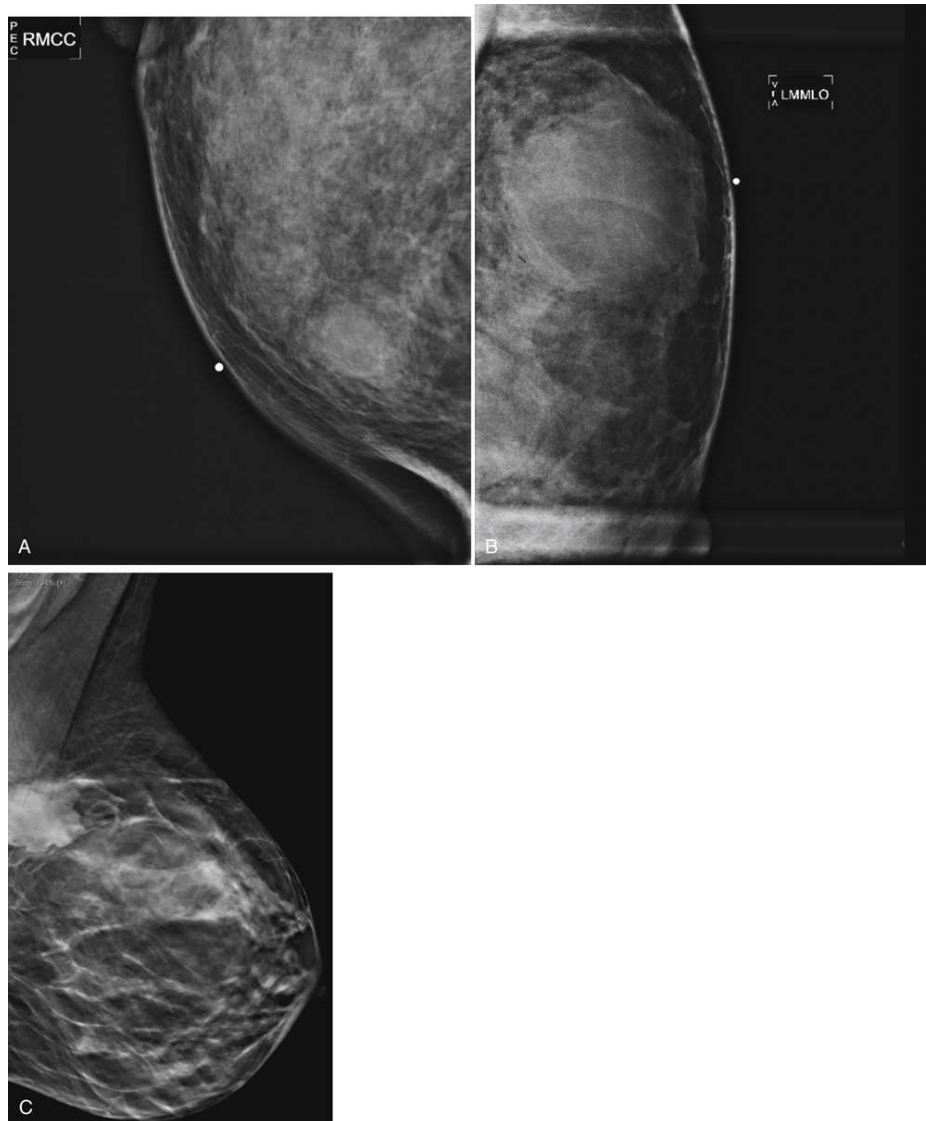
Circumscribed masses are often benign. (A) TAN MAG projection of a fibroadenoma. (B) Magnified view of a retroareolar cyst. A mass is determined to be solid or cystic (fluid-filled) on ultrasound. (C) DBT slice of a microlobulated mass, which proved to be malignant on biopsy.
